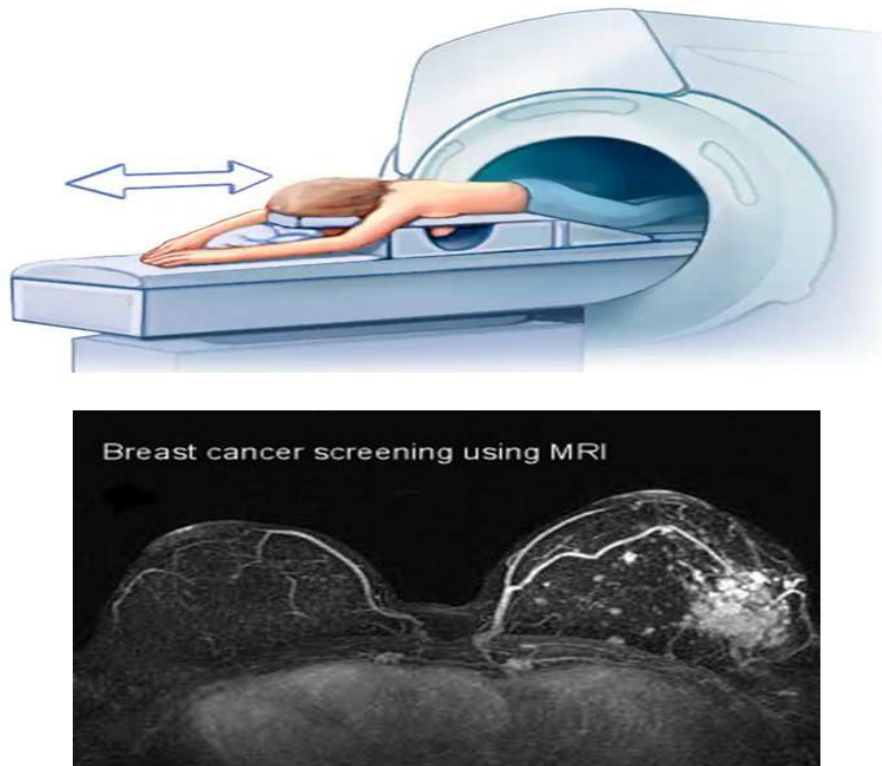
Magnetic resonance imaging for diagnosis of breast cancer
